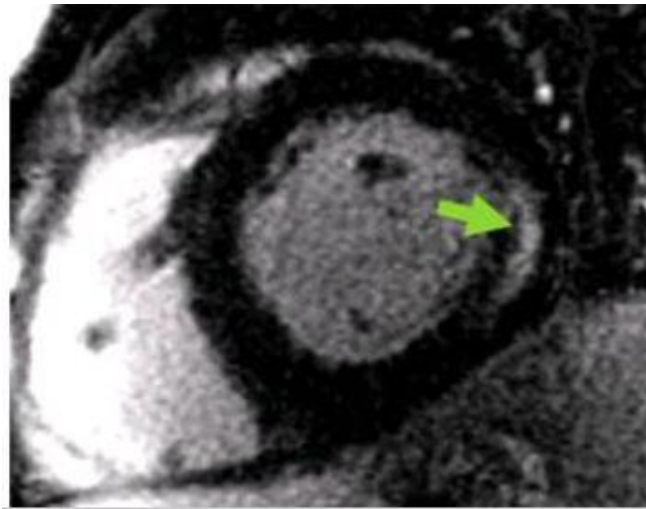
Cardiac MRI showing marked thickening of the left ventricle with late gadolinium enhancement in the basal posterolateral myocardial segments {Yousef, 2013 #310}.
